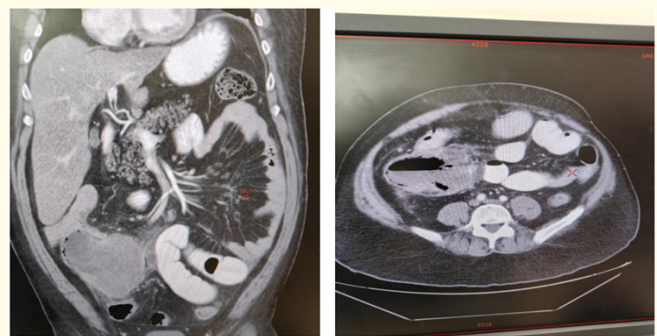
CT Images showing dilated Caecum with air fluid level and gangrenous changes in wall of caecu.
